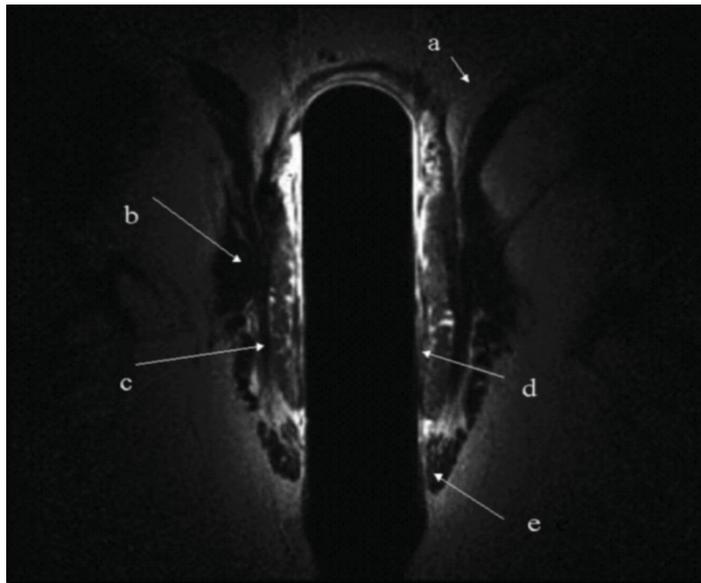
MRI of the anorectal canal with the anal rectal coil. (a) levator ani, (b) puborectal muscle, (c) anal internal sphincter, (d) longitudinal layers of the rectum, (e) anal external sphincter. From caudal to cranial the anal external sphincter is visualized first. The fibers of this muscle turn into the fibers of the puborectal muscle cranially. Encircled by these muscles is the internal anal sphincter together with the circular and longitudinal layers of the rectum.
